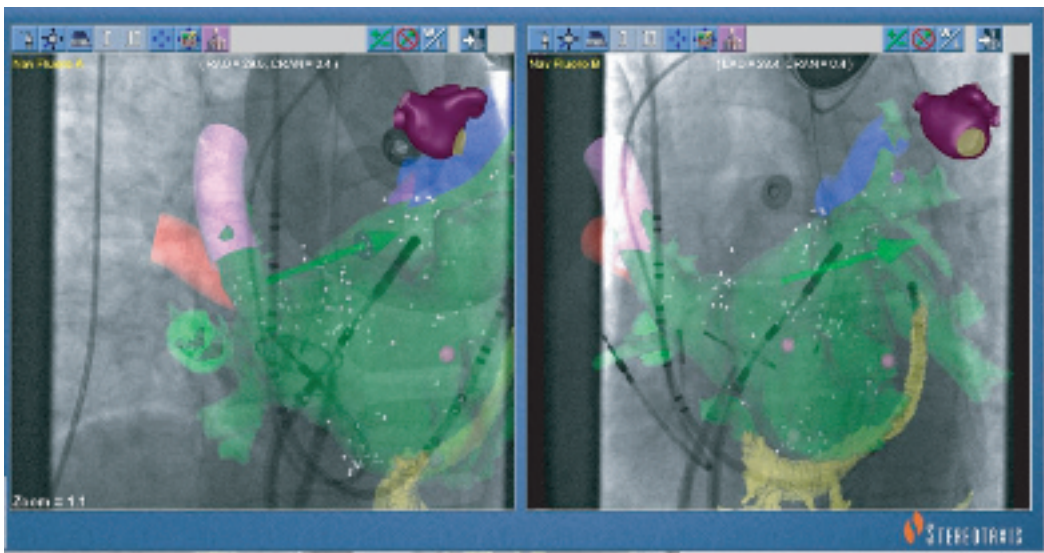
CT-CARTO integration with Fluoroscopy using Stereotaxis.
